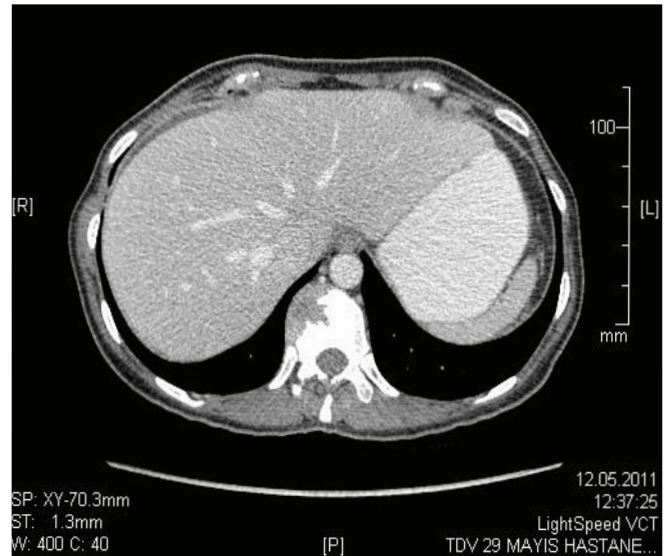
Lytic lesion with soft tissue component on 11th thoracal vertebra at abdominal CT
